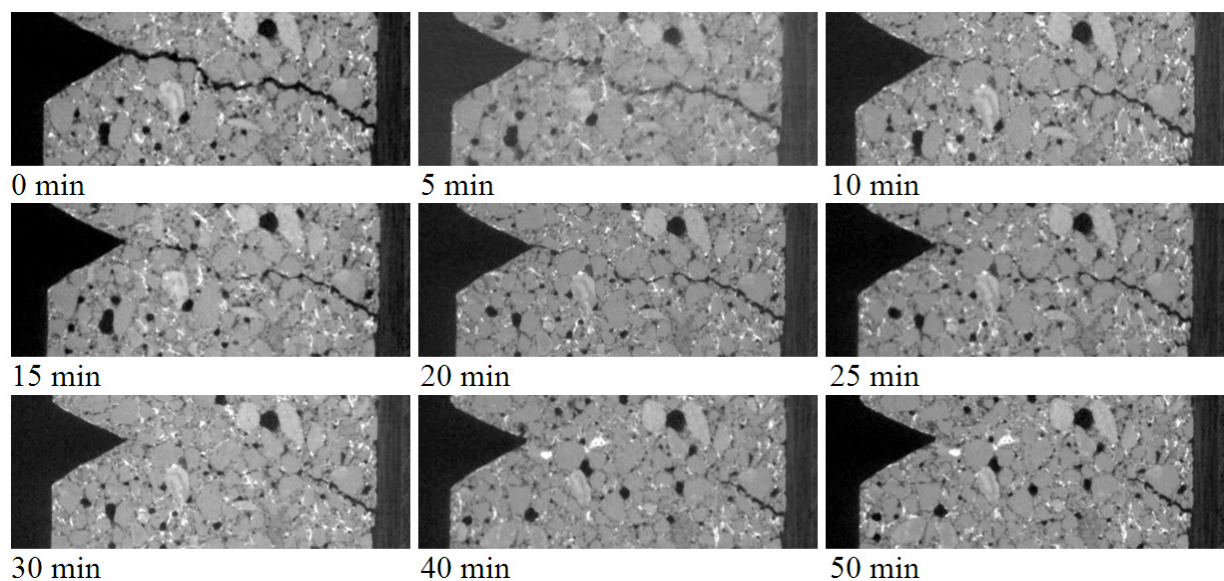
CT-Scan images of one section of the beam through the healing.
